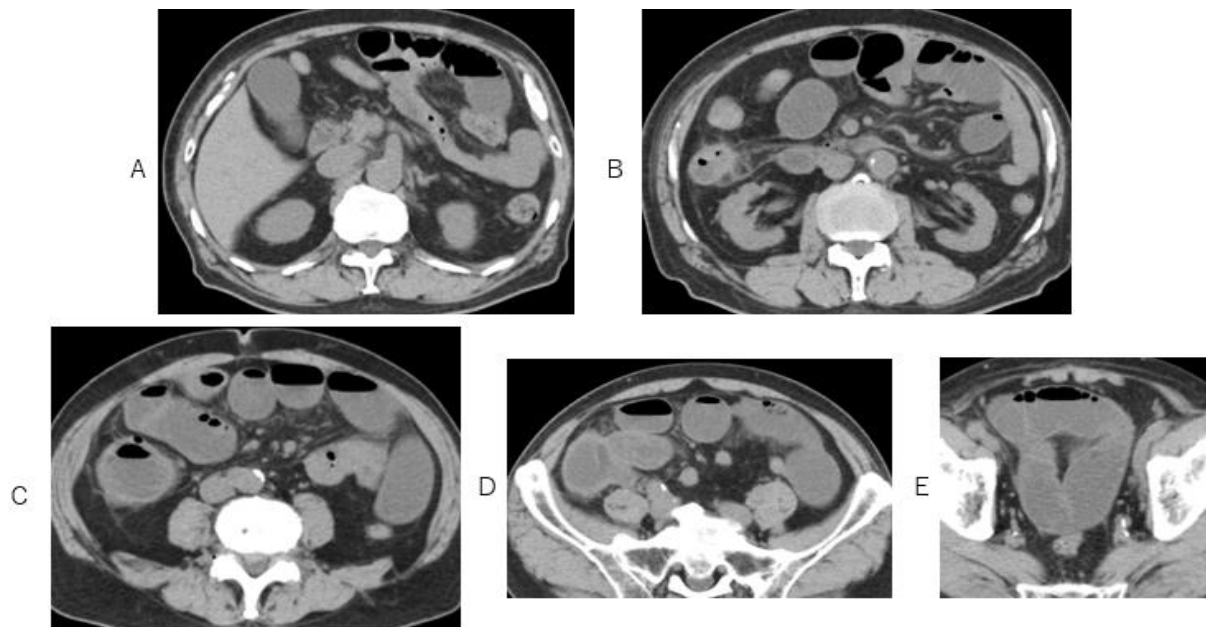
Axial CT images depict dilated small intestine with fluids and gas, diameters of small intestine are 3cm or greater.
